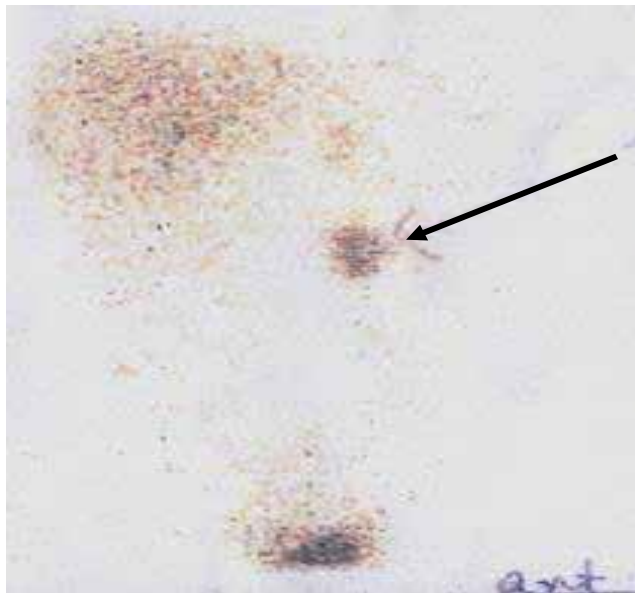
I¹²³-mIBG scintigraphy showing para aortic tumor.
